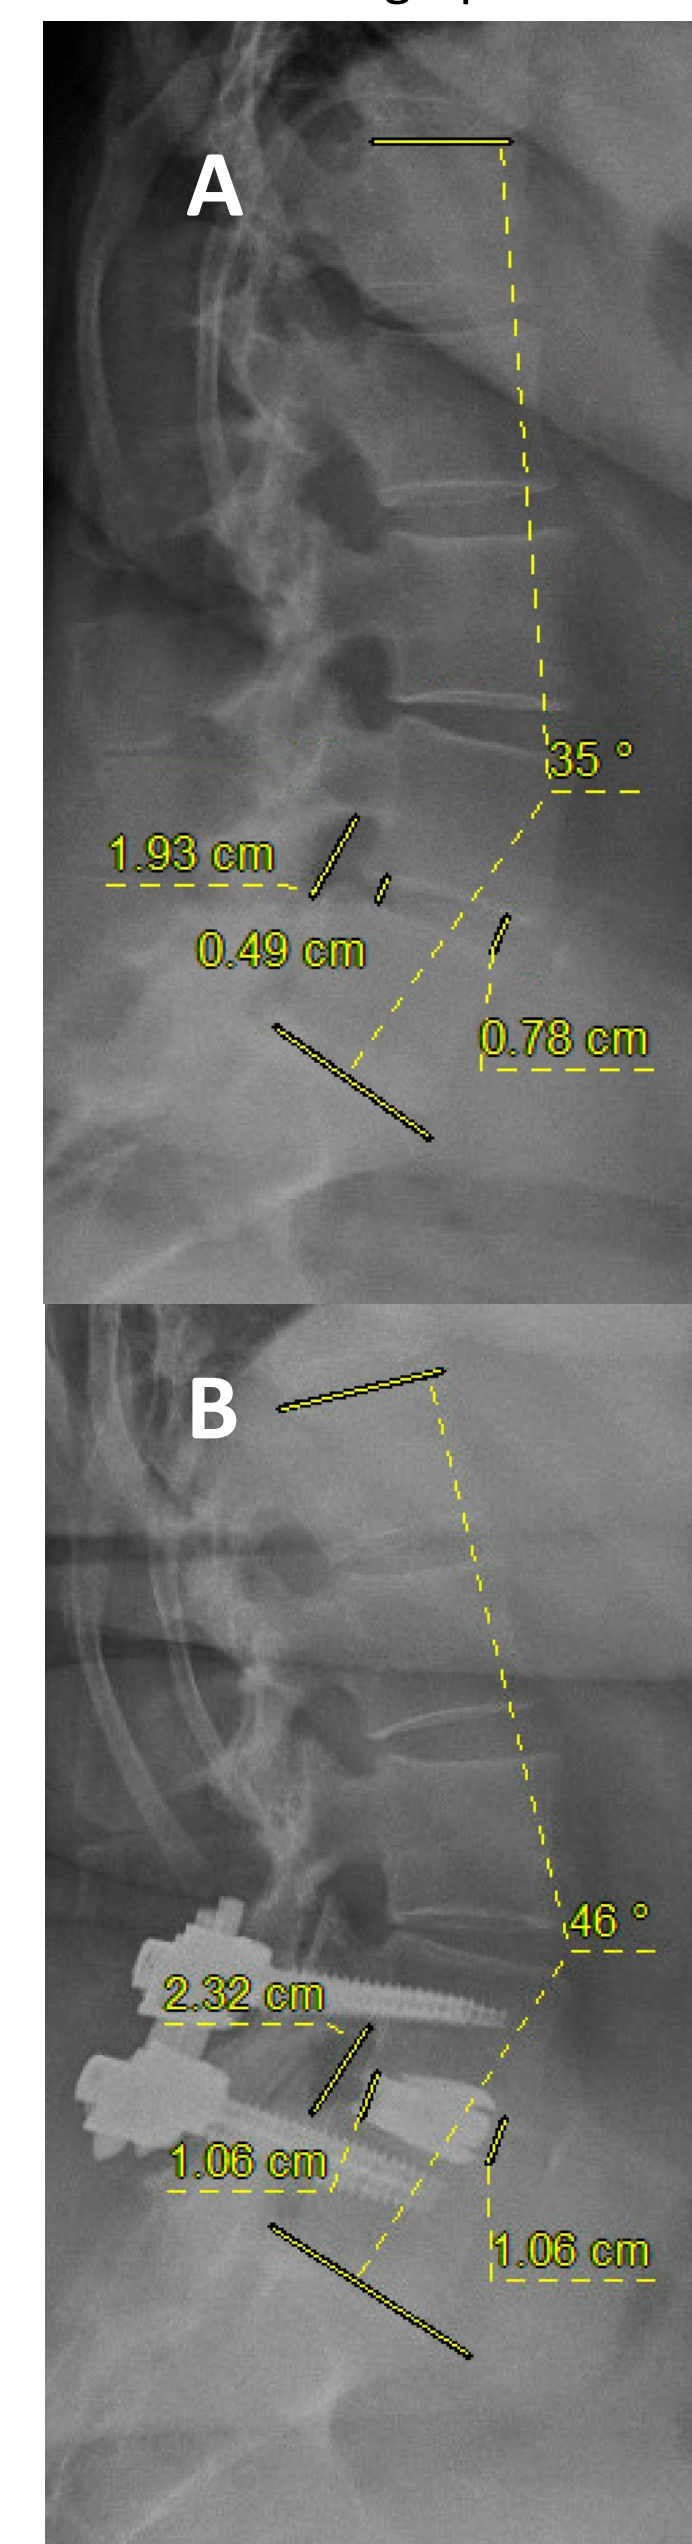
L4/L5 MIS ALIF pre-op (A) and 6-month post-op (B) radiographs. Diagnosis of stenosis and anterolisthesis. Bridwell grade 1 at 6 months
